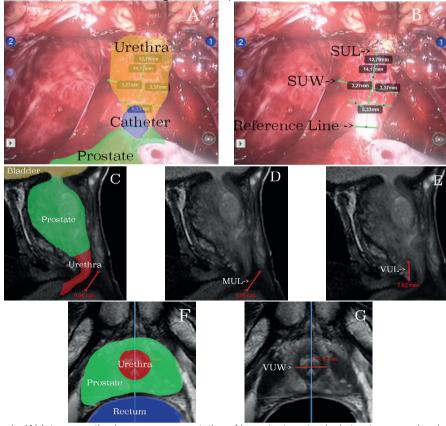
(A) Intra-operative image – representation of important anatomical structures used as landmarks during the measurements of the urethral stump; (B) intra-operative image – calibration lines overlapping the urethral stump with Foley 16 Ch catheter inserted used as reference structure; (C) axial and F: coronal MRI image - representation of important anatomical structures used as landmarks during the measurements of the urethral stump; (D) MUL, (E) VUL and (G) VUW measurement method on MRI images.
